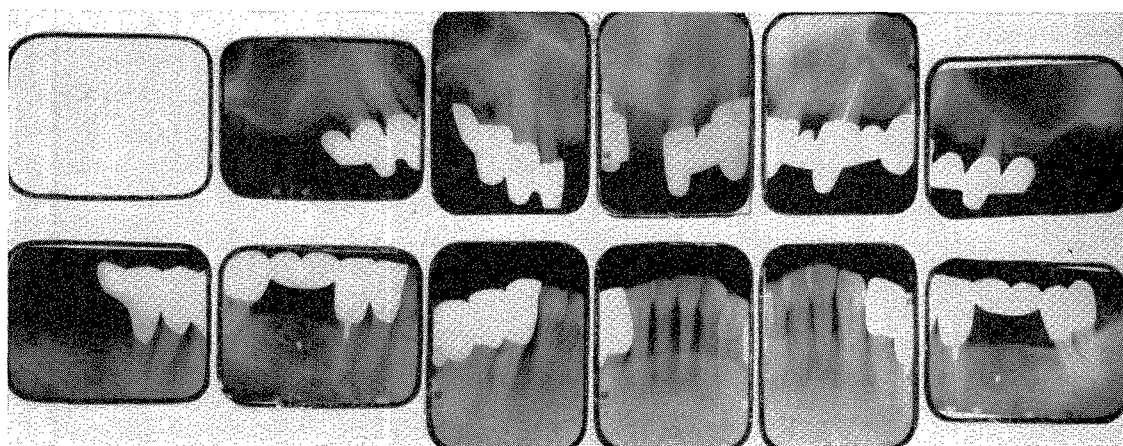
Roentgenograms taken in 1962. The upper left cuspid became nonvital and infected. Its root was treated through the gold coping and filled.
